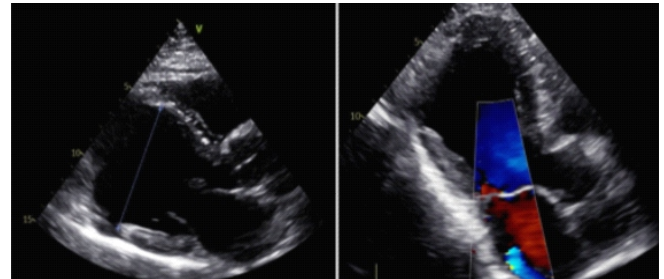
Transthoracic echocardiography showing adverse left ventricular remodeling and moderately dilated left ventricle (Left) Color Doppler image demonstrating moderate mitral regurgitation with a systolic regurgitant jet directed into the left atrium. (Right).
